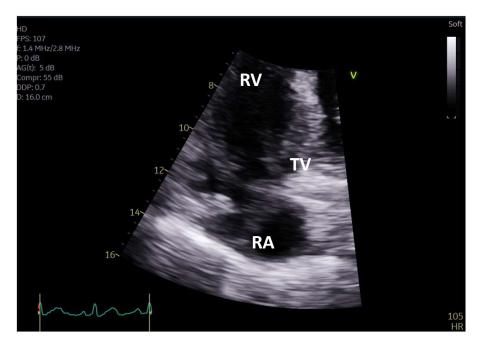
apical 4 chamber. Zoom on TV showing leaflet vegetations.
